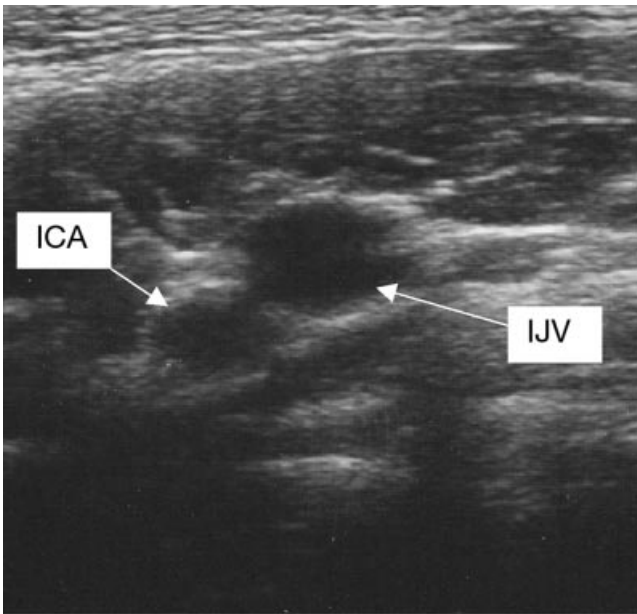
The internal jugular vein viewed with a 'SiteRite II' ultrasound machine at the time when the patient's face had become acutely oedematous. ICA=internal carotid artery; IJV=internal jugular vein (distended).
